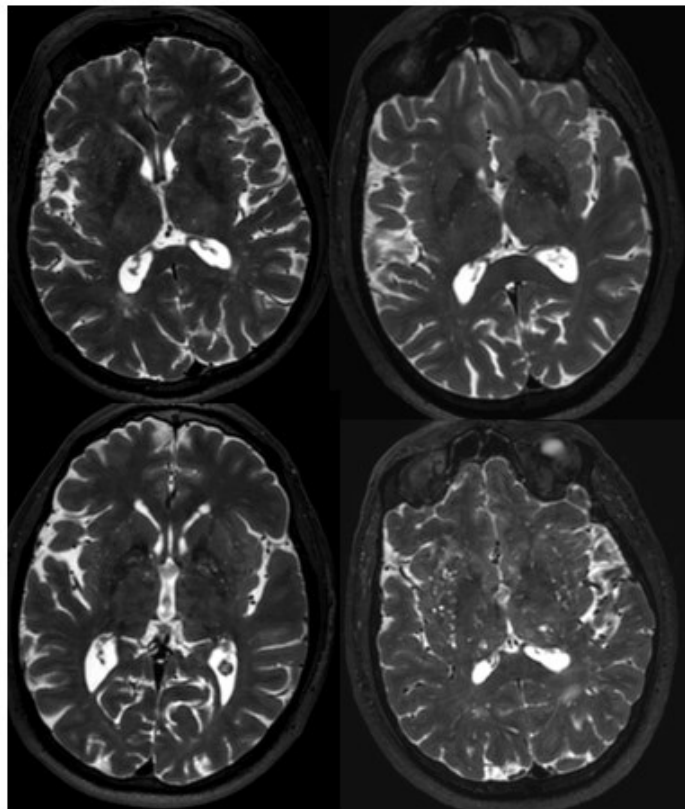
Axial T2-weighted MRI showing punctuate perivascular spaces in the basal ganglia (from left to right) grade 1, grade 2, grade 3 and grade 4. Examples are taken from MRI scans of STRADL participants.
